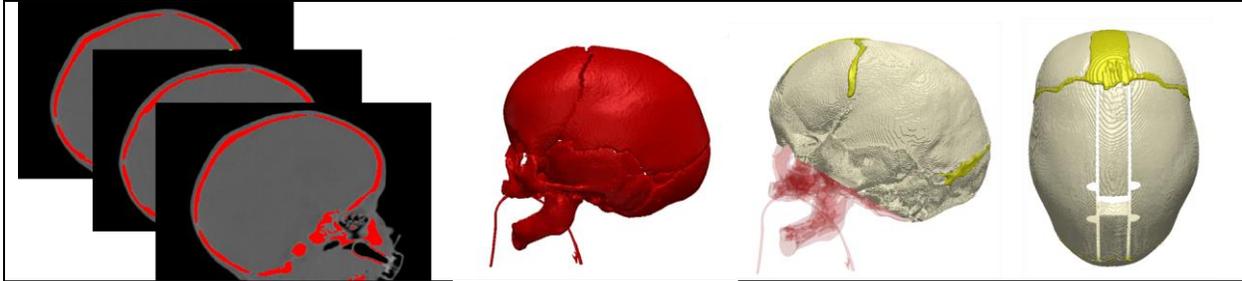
Creation of FE model for modelling of spring cranioplasty; segmentation of CT images (left); creation of a 3D skull model (centre-left); identification of the region of interest for the modelling (centre-right); reproduction of surgical osteotomies (right).
